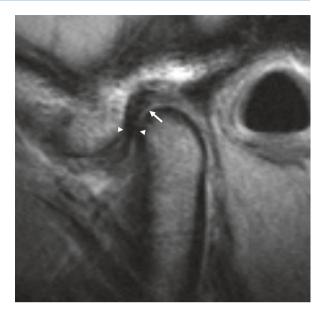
Images of a normal asymptomatic volunteer acquired with the 32-channel head coil shown in Fig. 10.2b at 3 T. (a) Sagittal MR image with the jaw closed. The biconcave, intermediate signal intensity disc (arrows) is situated in the normal relationship superior or 12 o'clock position relative to the condylar head and being between the anterior convexity of the condyle (C) inferiorly and the posterior convexity of the temporal bone. (b) Sagittal MR image with the jaw maximally opened shows the biconcave lenslike ("Bowtie") of the disc (arrows) in the normal position between the convex surface of the condyle (c) interiorly and the convex surface of the tubercle of the temporal bone superiorly. The condyle shows normal translation just beyond the tubercle. (c) The normal temporal posterior attachment (arrows) is well depicted in the opened jaw position. The posterior attachment expands on opening. (d) Coronal MR image of the right TMJ of the same subject with the jaw in the closed position. The disc (arrows) is in a normal position and has an arc-like configuration
